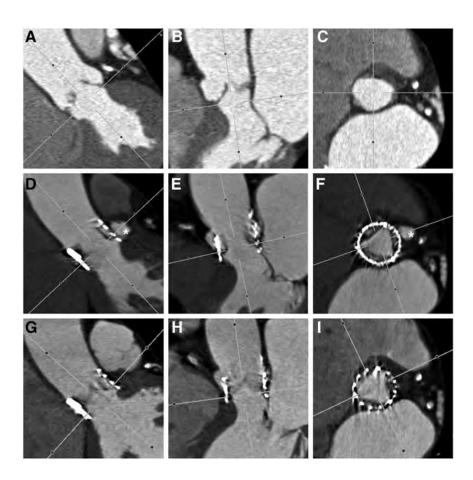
A 77-year-old female patient with aortic stenosis (A-C) pre-TAVI multislice computed tomography) and contained rupture (*) status post-TAVI (D-F) and spontaneous remission on further follow-up CT (G-I). The first column depicts the coronal-oblique views, the second column represents the sagittal-oblique views, and the third double-oblique transverse views. TAVI indicates transcatheter aortic valve implantation.
